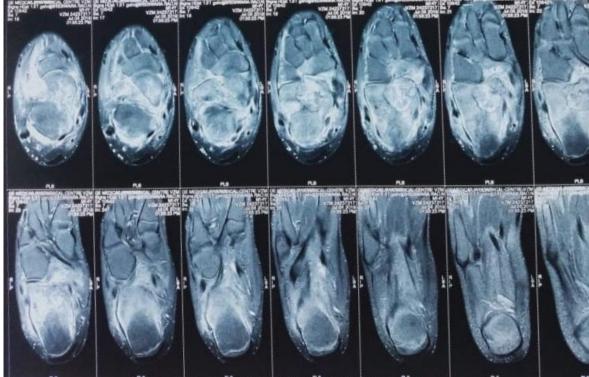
MRI axial cuts showing lesion in calcaneum.
